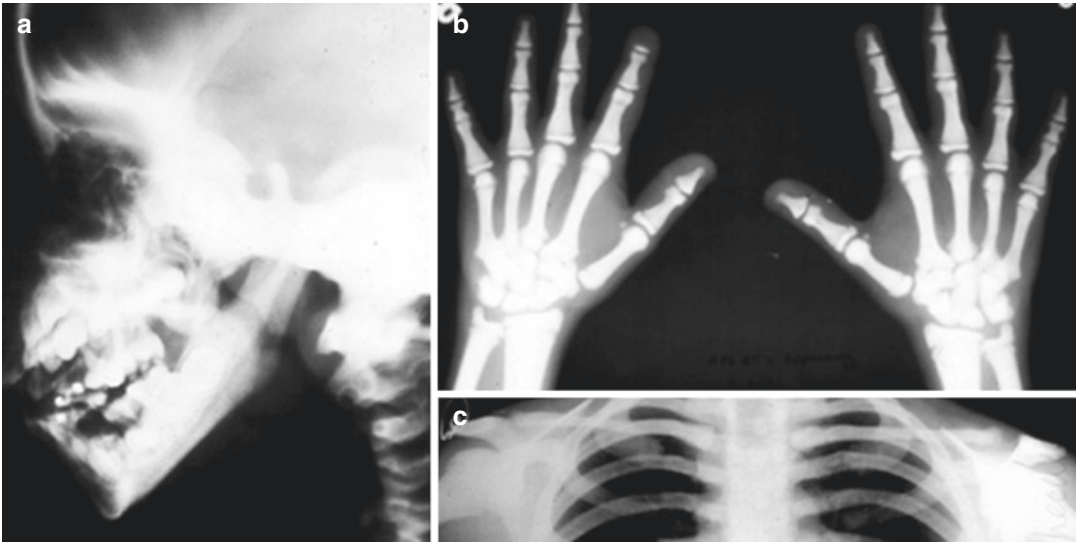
Skeletal survey in a patient with pyknodysostosis. (a) Oblique radiograph of the mandible shows osteosclerosis with obtuse angle of the mandible. (b) Frontal radiograph of both hands shows terminal phalangeal hypoplasia mimicking acro-osteolysis (apart from
